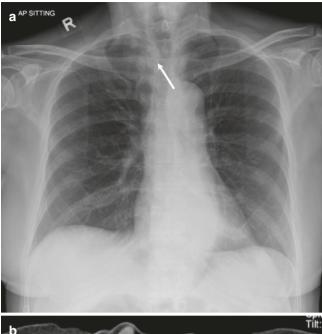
51-year-old woman with stomach cancer. (a) Frontal radiograph shows indentation on the right lateral wall of the trachea with subtle focal thickening of the paratracheal stripe (arrow). (b) Axial CT image reveals a metastatic right paratracheal lymph node (arrow)
